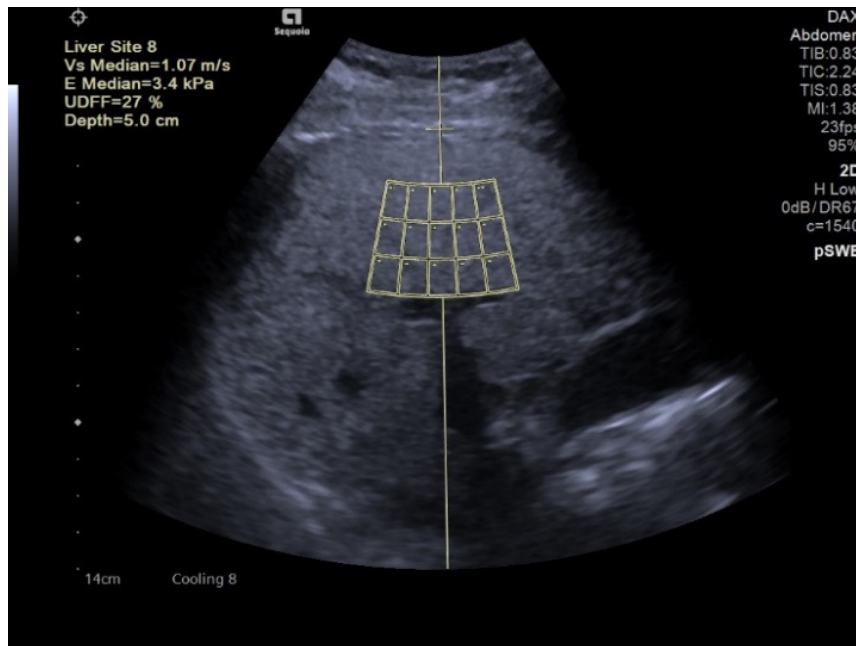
UDFF (Ultrasound Derived Fat Fraction) developed by Siemens™.
